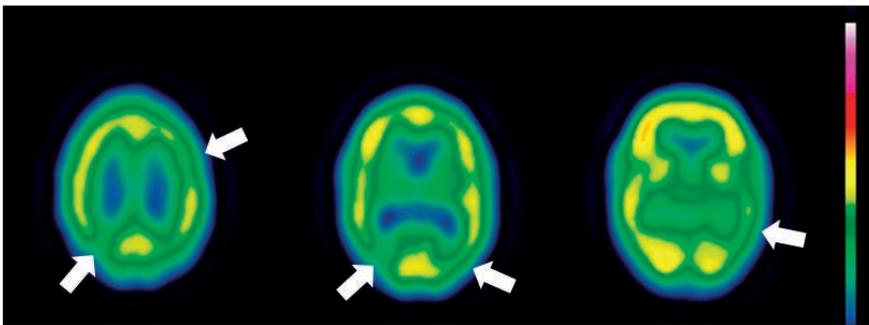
A patient with SLE presented with clinical features suggestive of neurolupus. SPECT shows multiple areas of hypoperfusion in the left frontal and bilateral parietal cortex consistent with neuropsychiatric SLE.
